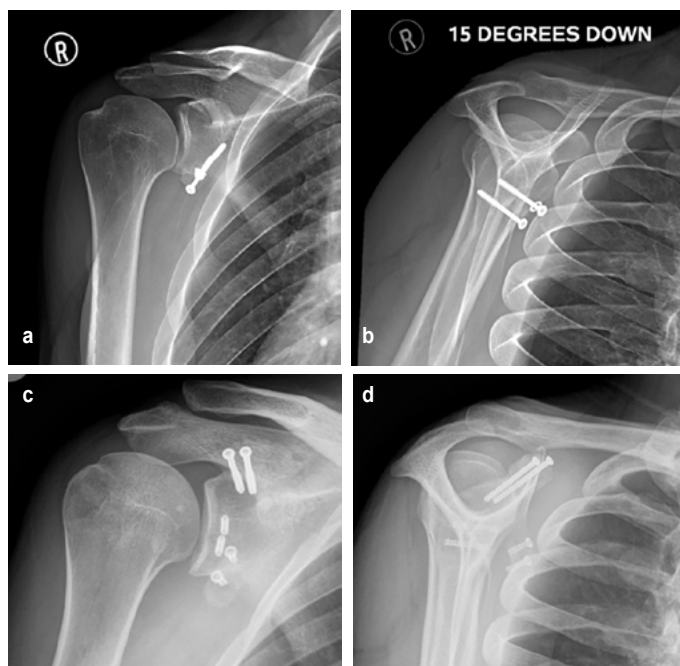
Postoperative X-rays of patients who underwent Latarjet procedure: a) showing bone-block resorption around the screw heads; b) showing bone-block nonunion represented by clear radiolucent line; and c) & d) AP and lateral view X-rays showing bone-block fracture with screw breakage
